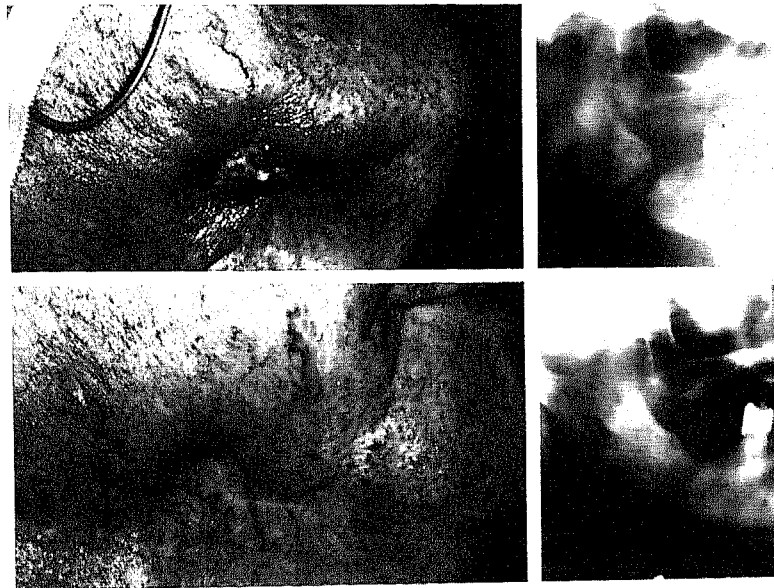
Above, left*, Clinical view of osteoradionecrosis presenting in Stage III after 7600 rads of external beam supervoltage radiation. *Above, center*, Panoramic view of same patient, showing osteolytic process into ramus. *Below, left*, Clinical view of same area after Stage III therapy and reconstruction in Stage III-R. *Below, center*, Panoramic radiograph of same patient after Stage III therapy and reconstruction in Stage III-R. *Right*, Technetium 99 Diphosphonate bone scan of same patient, showing viability of graft.
